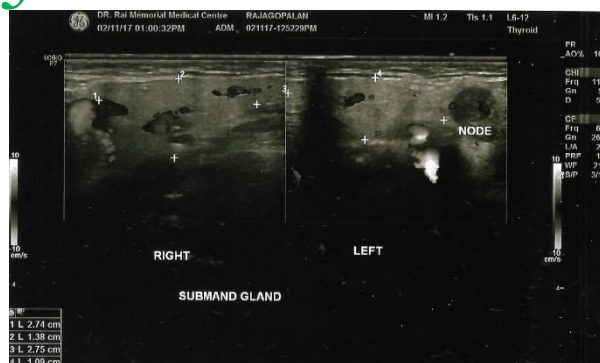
Ultrasound images of metastatic cervical lymph nodes.
